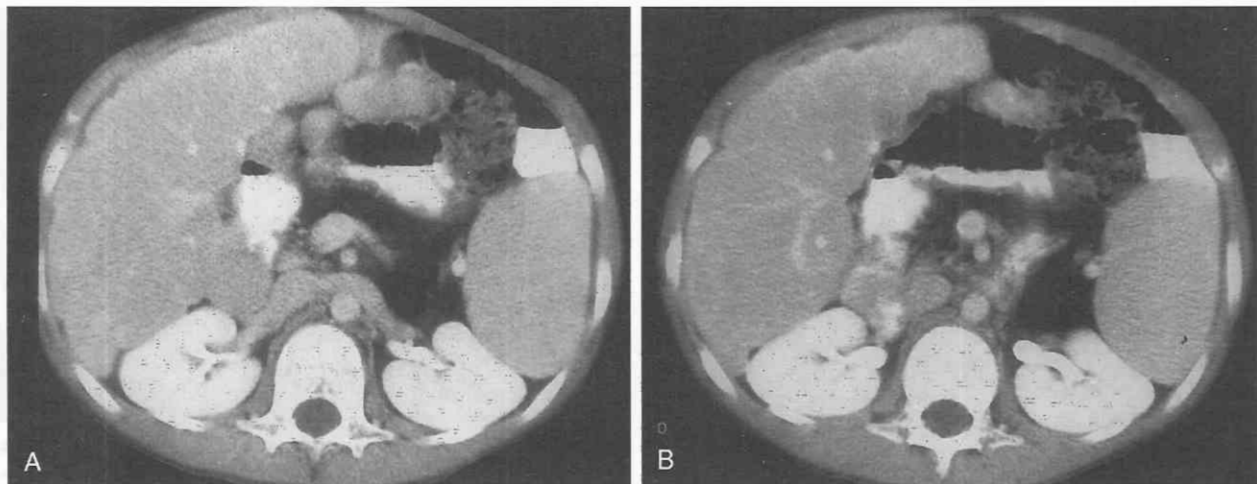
Fatty replacement of the pancreas in cystic fibrosis. CT scans through the body and tail of the pancreas (A) and through the head of the pancreas (B) in a patient with cystic fibrosis demonstrate diffuse low attenuation of the pancreas indicative of diffuse fatty infiltration.
